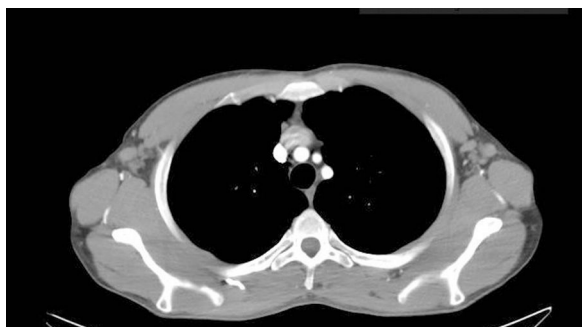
Patient 4. Computed tomography scan of chest and abdomen: enlarged bilateral axillary lymph nodes with a diameter of up to 13.7 mm at the narrowest point on both sides.
